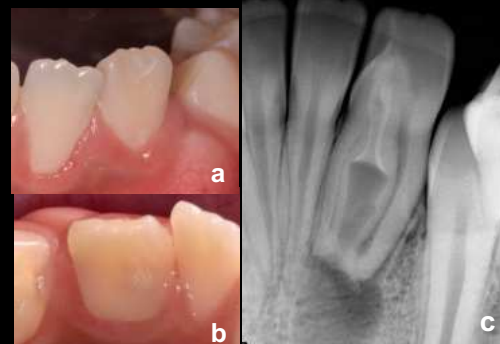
(a and b), Preoperative clinical image. (c), Initial X-ray.
